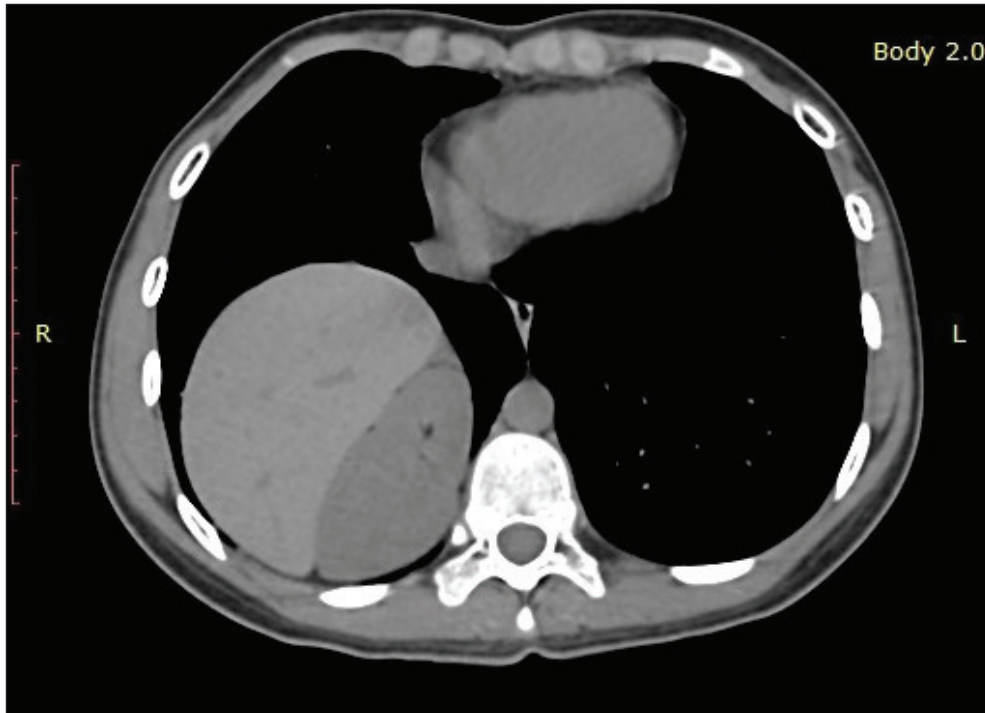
CT cross-sectional view showing right thoracic kidney, right lobe of liver, and left lung.
